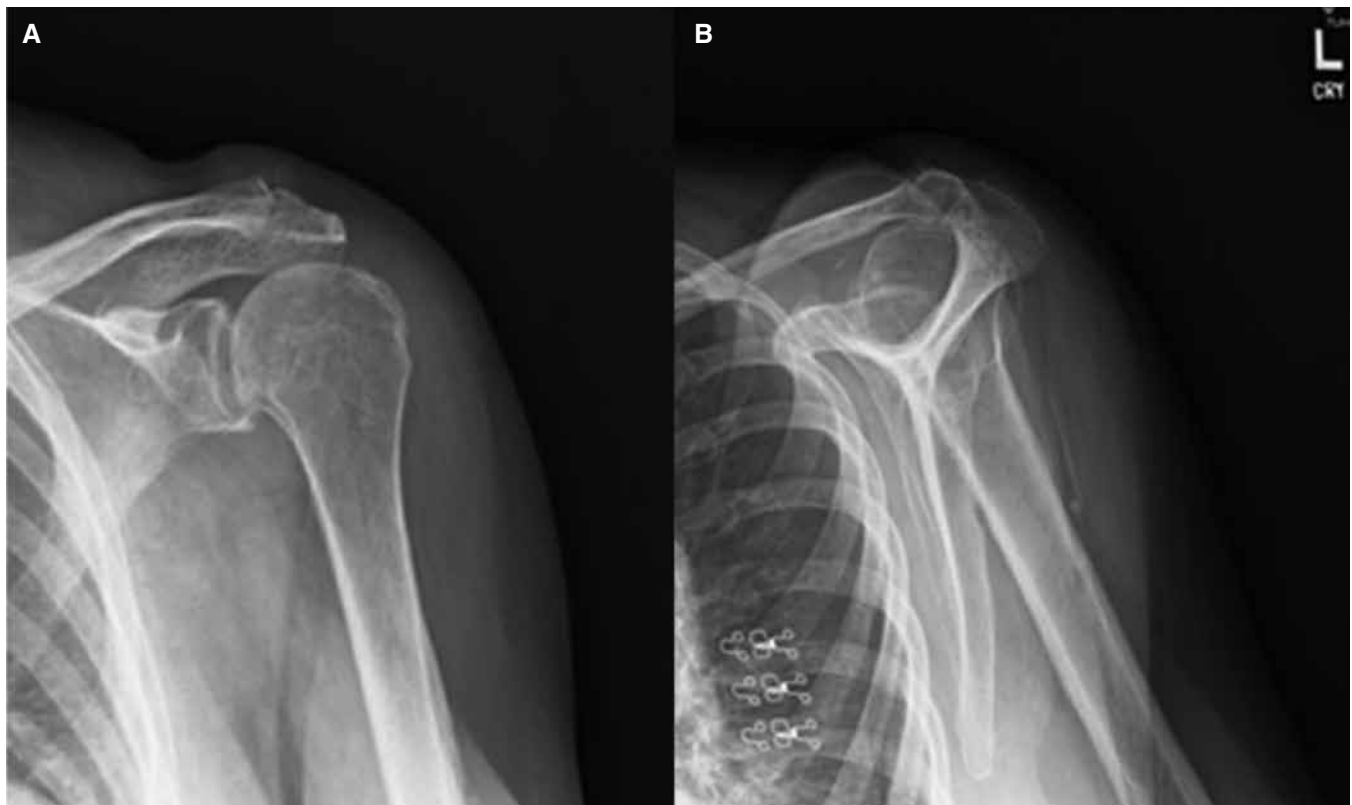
(A) An anteroposterior radiograph in external rotation and (B) A trans-scapular Y-view of the left shoulder demonstrating arthropathy of the acromioclavicular and glenohumeral joints with bony hypertrophy at the greater tuberosity.
